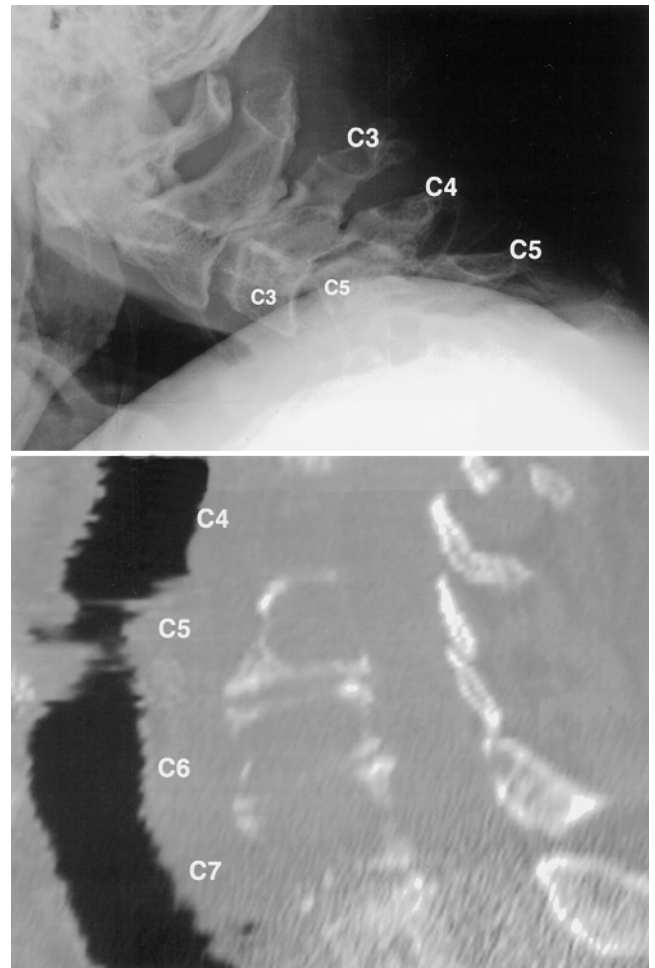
Case 1. *Upper*: Preoperative lateral cervical spine radiograph revealing subluxation at C3–5. *Lower*: Sagittal computerized tomography reconstruction of the cervical spine after reduction procedure, demonstrating myelomatous replacement of vertebral bodies.
